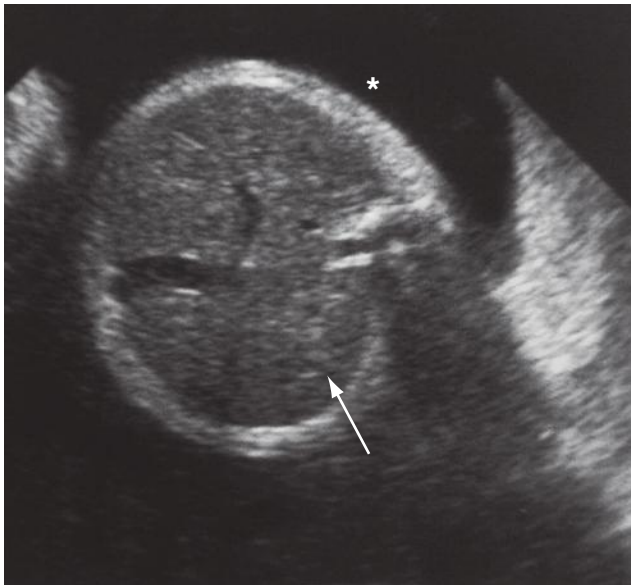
Sonogram of a patient with esophageal atresia and polyhydramnios showing absence of the fetal stomach (arrow) and increased amniotic fluid (asterisk).
